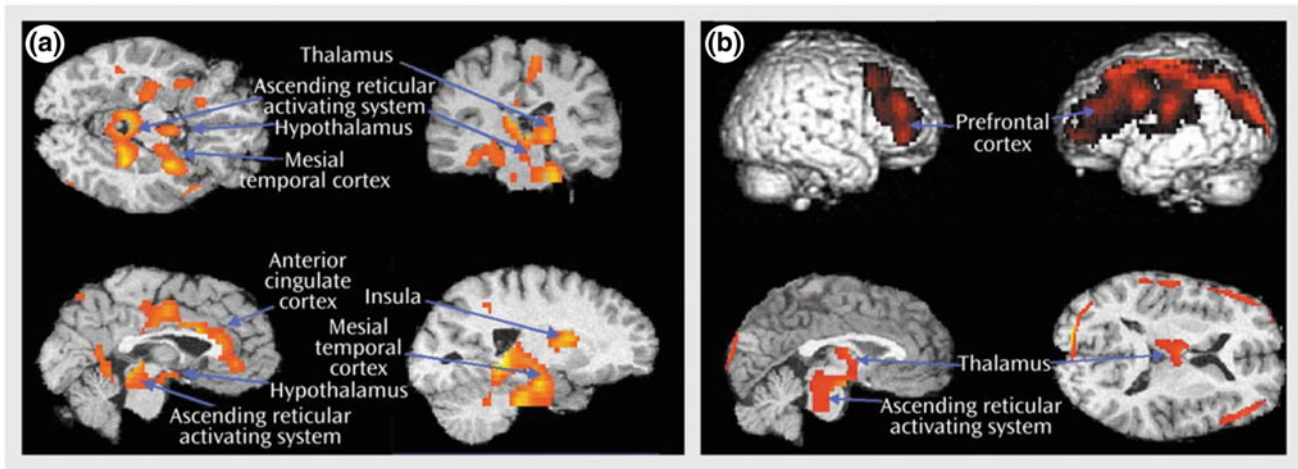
CMRglu assessed by ^{18}F FDG PET in insomniacs (versus healthy subjects) during waking and NREM sleep. a Brain structures that did not show decreased cerebral metabolic rate of glucose (CMRglu) from waking to sleep states in patients with idiopathic insomnia. b Brain structures where relative metabolism while awake
